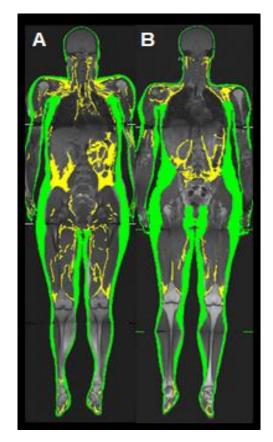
Whole body magnetic resonance imaging (MRI). MRI allows us to detect differences in fat deposition and provide a more accurate assessment of metabolic health. Subject A on the left has a lower volume of overall adipose tissue (in green), but more visceral fat (in yellow) in the abdomen compared to subject B on the right. These data indicate that despite being more obese by conventional measures, subject B is metabolically healthier than subject A.
